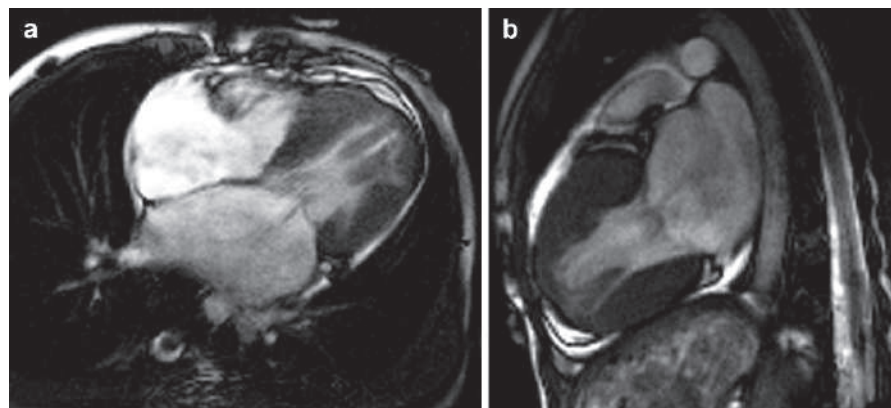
Four-chamber white-blood cardiac MRI (a) and two-chamber view (b) show concentric hypertrophic cardiomyopathy (HCM). Notice the thickened chorda tendinae in (a)
